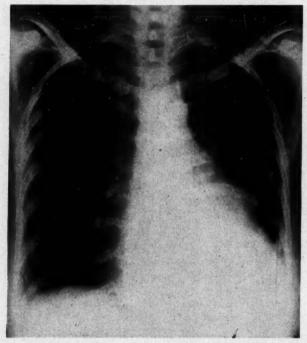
Chest x-ray of patient taken shortly before death, showing left ventricular enlargement and pulmonary congestion. The absence of any part of the cardiac shadow to the right of the sternum is characteristic of severe pectus excavatum.
